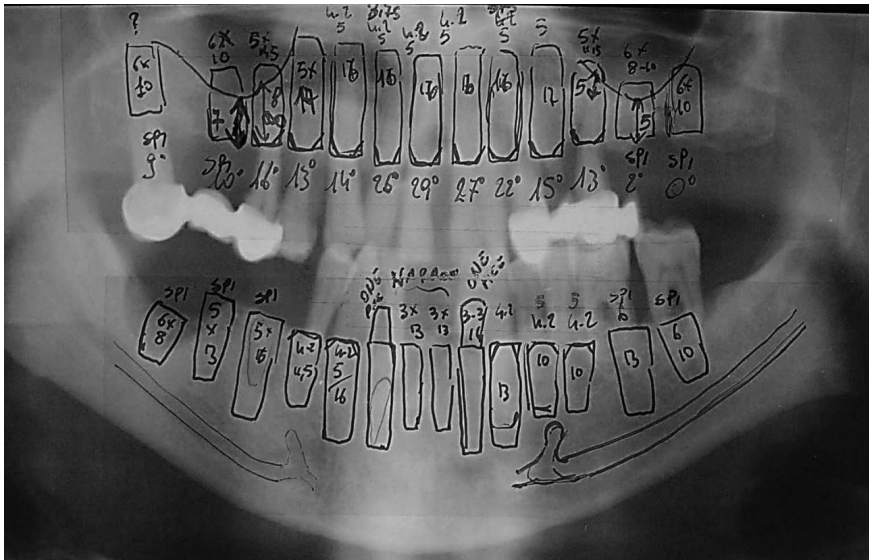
Preliminary locations and types of implants were selected from Orthopantomogram
